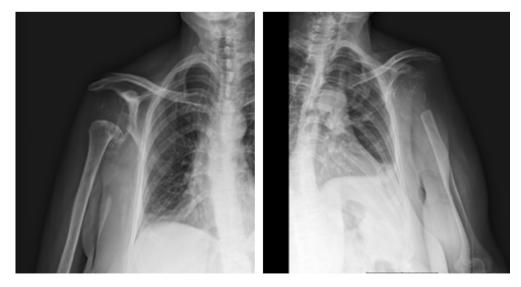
Bilateral humerus X-ray. X-ray showed that right humerus radiolucent foci(osteolytic lesions) and loss of tissue and left humerus proximal resorption of bone.
